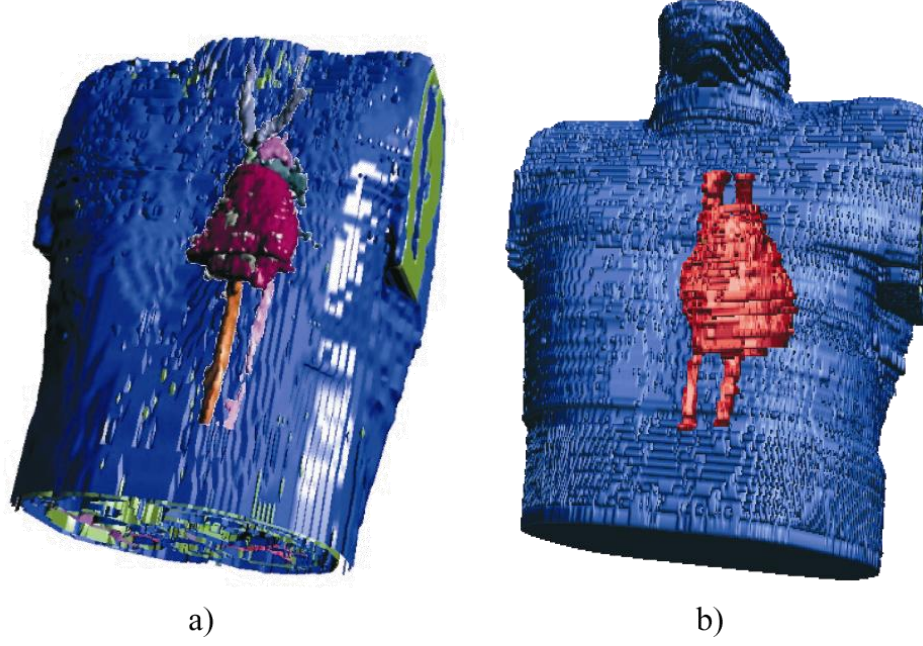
The realistic 3D thorax models: (a) model based on the visible human man project; (b) model based on magnetic resonance images presenting the anatomy during diastole [I].
